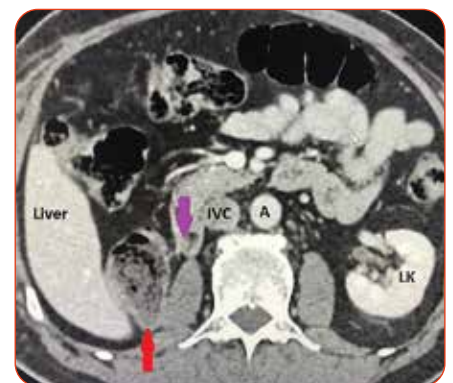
Enhanced axial CT scan showing right nephrectomy. Large bowel (red arrow) and small bowel (purple arrow) in region of the right renal bed. LK = left kidney. A = aorta. IVC = inferior vena cava.
